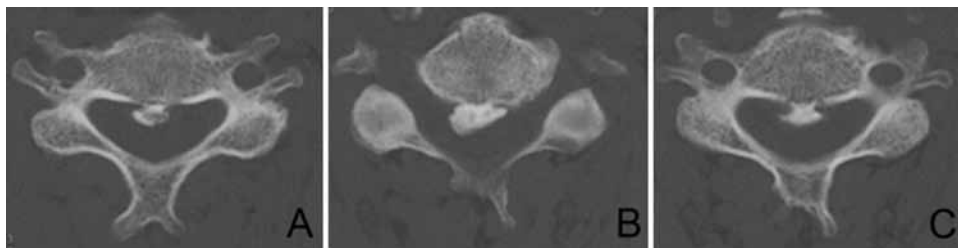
Axial CT scans demonstrating OPLL. Segmental OPLL is seen in all 3 images.
